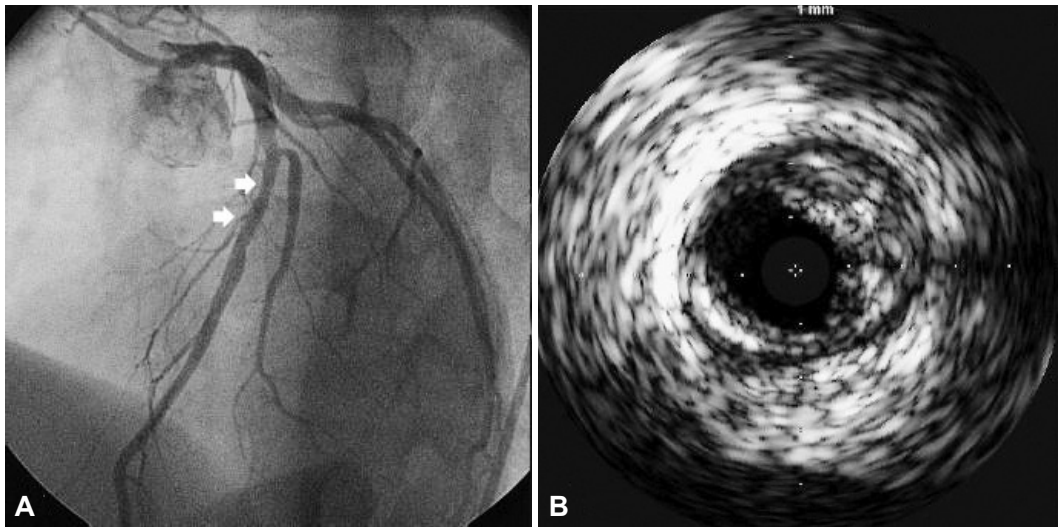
A: left coronary angiography showed mild type II in-stent restenosis in the left anterior descending artery (LAD). B: intravascular ultrasound revealed a plaque in the LAD stent.
